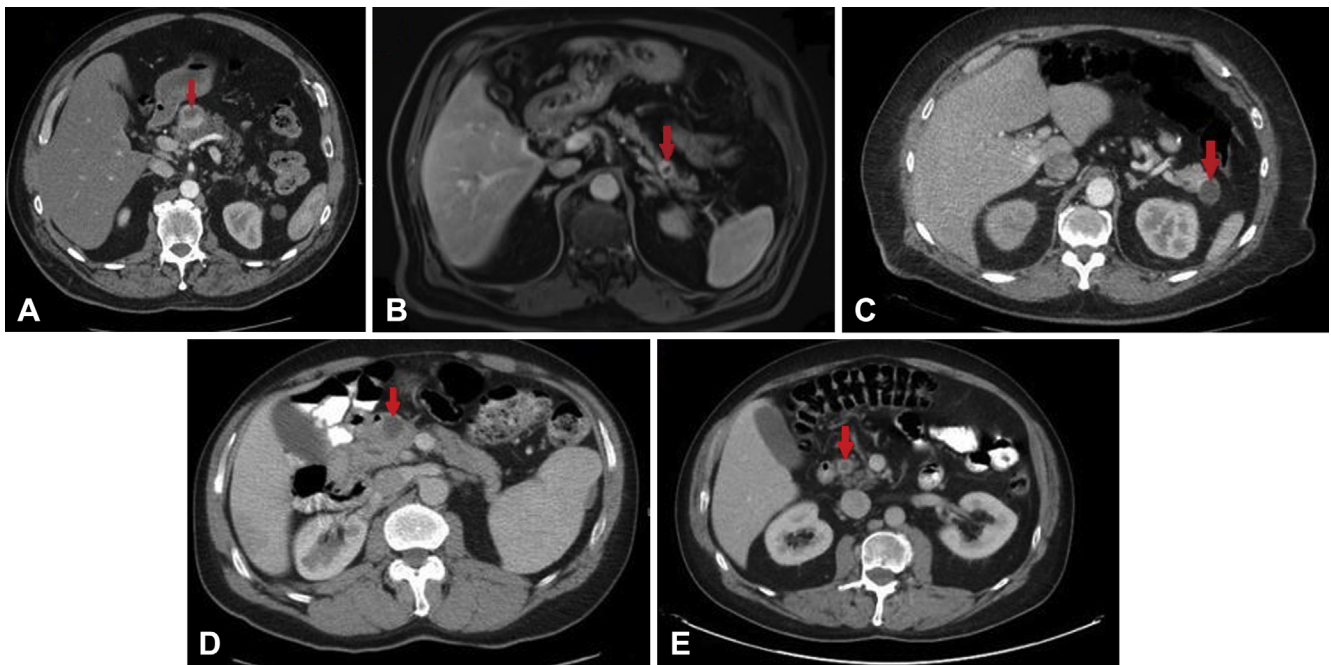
A, Patient 1: abdominal CT with a 2.8-cm cystic and solid pancreas mass. B, Patient 2: abdominal MRI with a 1.2-cm pancreas cyst. C, Patient 3: abdominal CT with a 3-cm pancreas cyst. D, Patient 4: abdominal CT with a 2-cm pancreas cyst. E, Patient 5: abdominal CT with a 1.2-cm pancreas cyst. *MRI*, magnetic resonance imaging.
